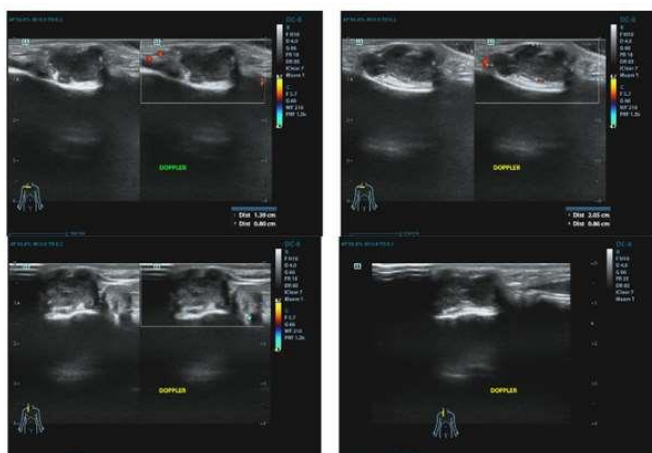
Echsonography, CEMA by FIFA
